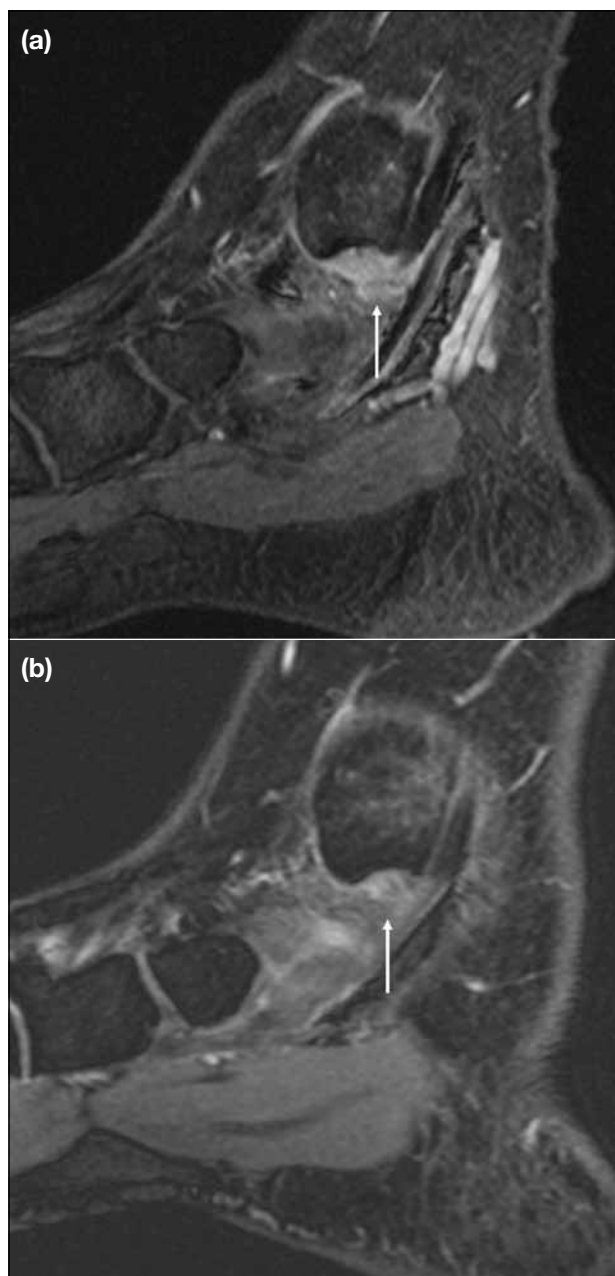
Post-gadolinium sagittal T1-weighted magnetic resonance imaging ankle (a) before synovectomy shows moderate synovial thickening and enhancement in the subfibular region of the ankle joint (white arrow), and (b) 12 months after synovectomy shows reduction of synovial thickening and enhancement in the subfibular region of the ankle joint (white arrow). This suggests a good response.
